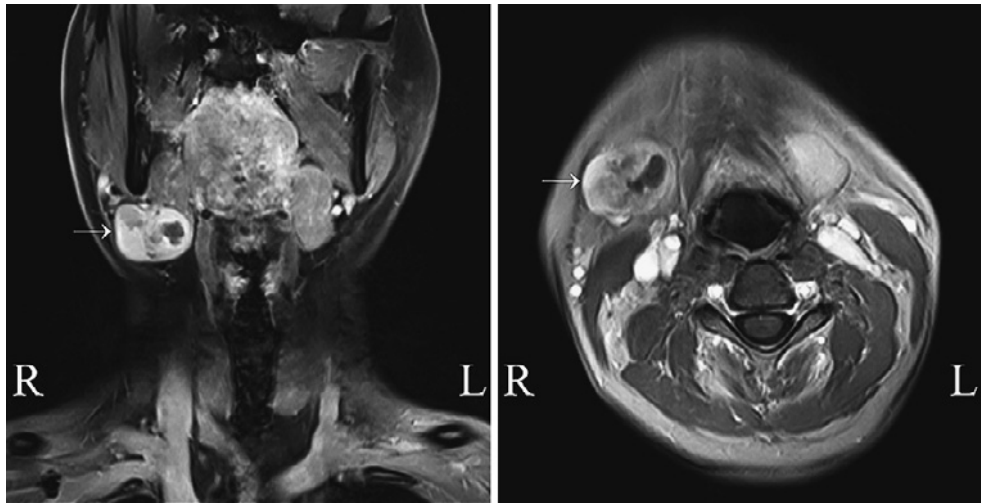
Enhanced MRI showing a right submandibular gland mass with a smooth margin and uneven enhancement.
